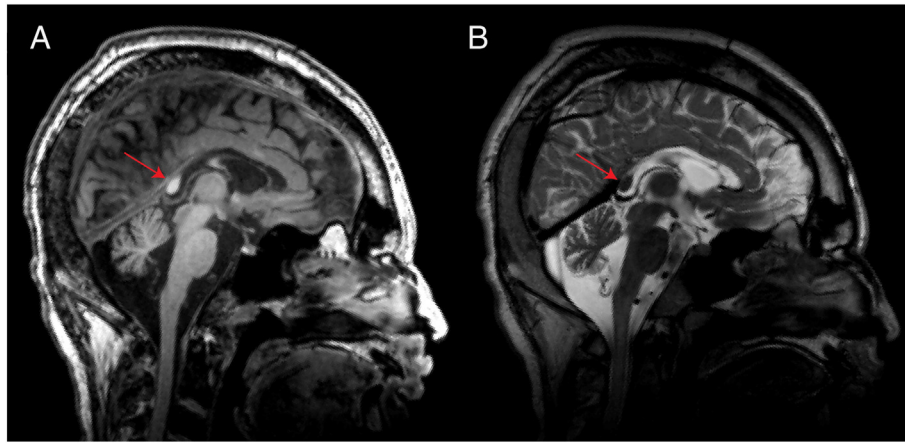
Splenium remnant. Saggital T1W (A) and T2W (B) MRI images of the patient's remaining splenium remnant status-postpartial corpus callosotomy. This remaining anatomic remnant of the corpus callosum was the anatomic target of our MRI-guided stereotactic laser interstitial thermal ablation of the splenium.
